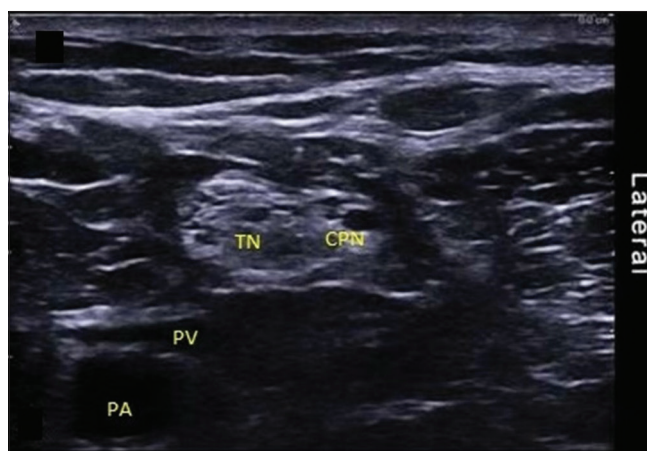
Ultrasound image of the bilobular pattern popliteal sciatic nerve at the level of nerve bifurcation. CPN = common peroneal nerve, PA = popliteal artery, PV = popliteal vein, TN = tibial nerve
